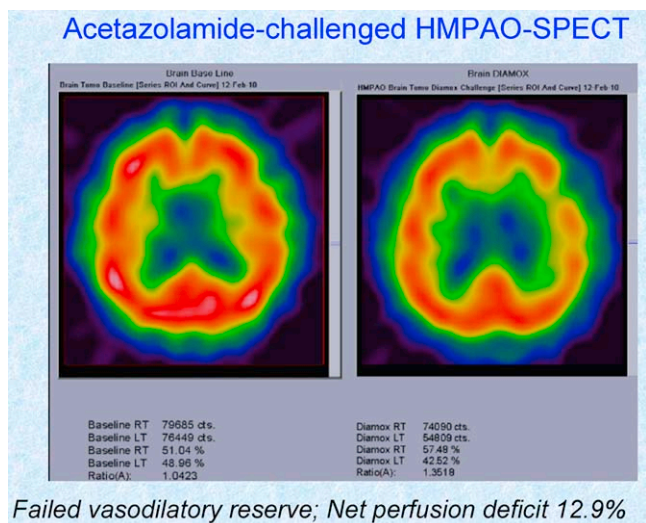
HMPAO SPECT (single-photon emission computed tomography) imaging after acetazolamide (Diamox) challenge shows a paradoxical reduction in the left MCA territory perfusion (net perfusion deficit 12.9%) resulting from the Reversed Robin Hood Syndrome in a patients with acute cerebral arterial ischemia due to left terminal internal carotid artery occlusion.
